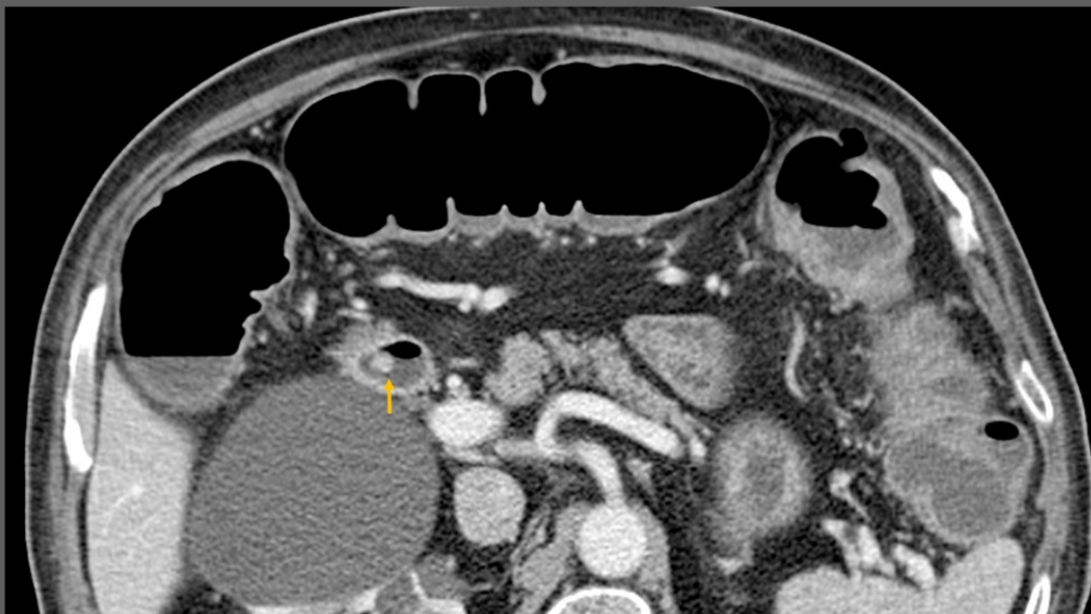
Adenocarcinoma. Axial CT enterographic section depicts a small polypoid lesion in the second portion of the duodenum. Pathologic examination revealed adenocarcinoma.
